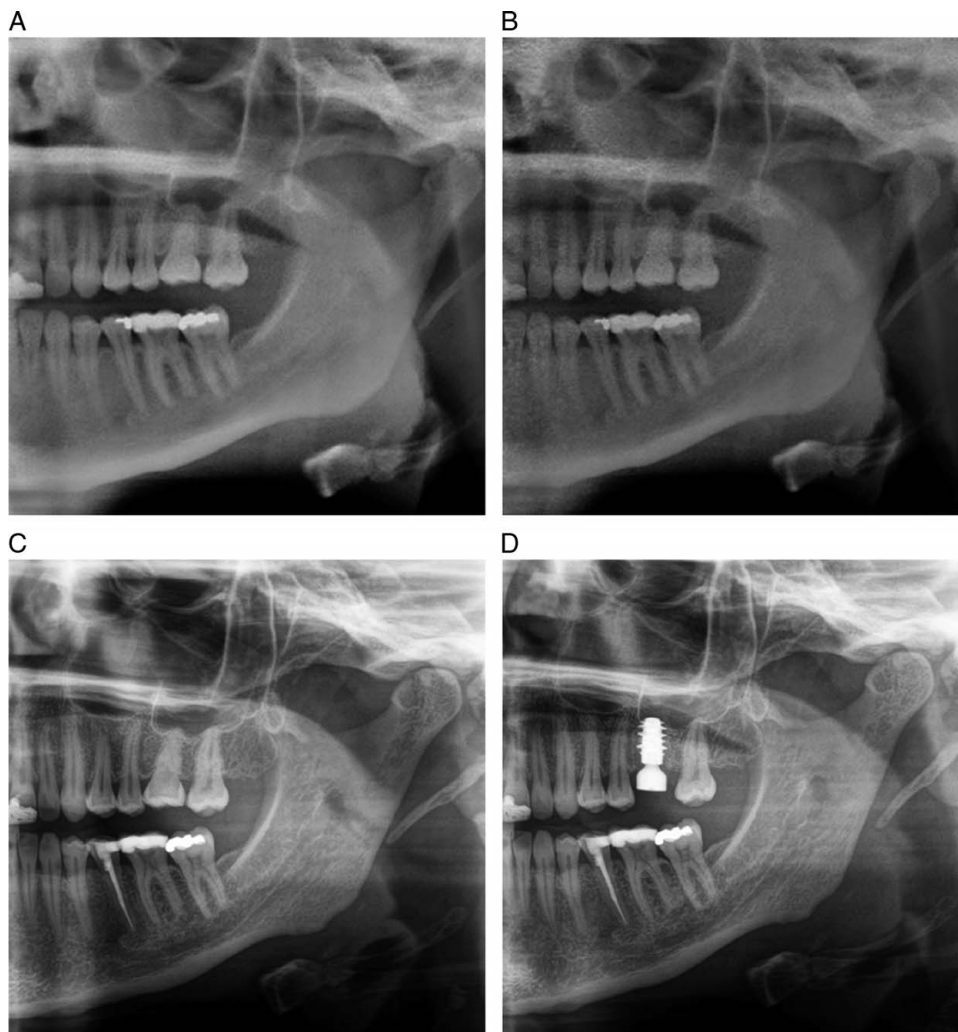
(A) Panoramic radiograph (OPG): recall after 4.5 years. (B) OPG: recall after 8 years. (C) OPG: recall after 17 years. (D) OPG: osseointegrated implant region 26.
